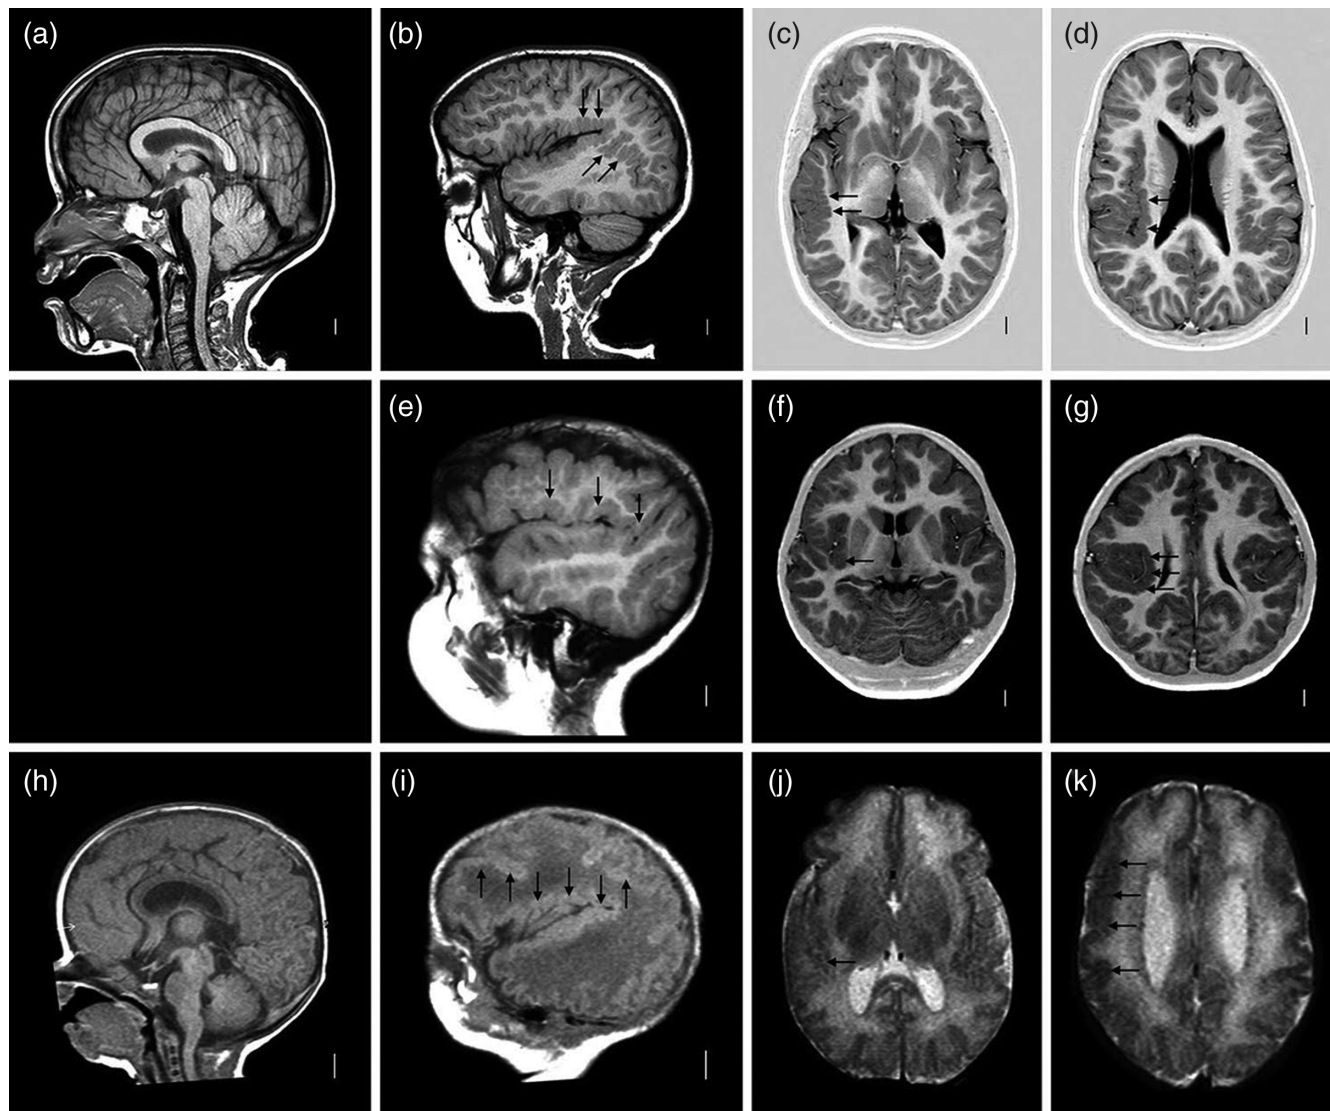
Brain magnetic resonance images in subjects PS-10203 (a–d), LP99-112 (e–g) and LR00-173 (h–k) with intrachromosomal 2p duplication. Midline sagittal images in two children (a, h) revealed mildly prominent foreheads with normal midline brain structures. Parasagittal images through the Sylvian fissure (b, e, i) and axial images at the level of the basal ganglia (c, f, j) or high lateral ventricles (d, g, k) show polymicrogyria (black arrows) in the perisylvian regions with extension posteriorly in patient PS-10203 (lower black arrows in b) or anteriorly in patients LP99-112 (e–g) and LR00-173 (i–k)
